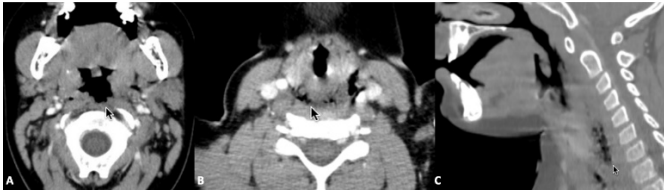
The traumatic region at posterior oropharynx (A) and subcutaneous emphysema at axial (B) and sagittal (C) sections of neck CT.
